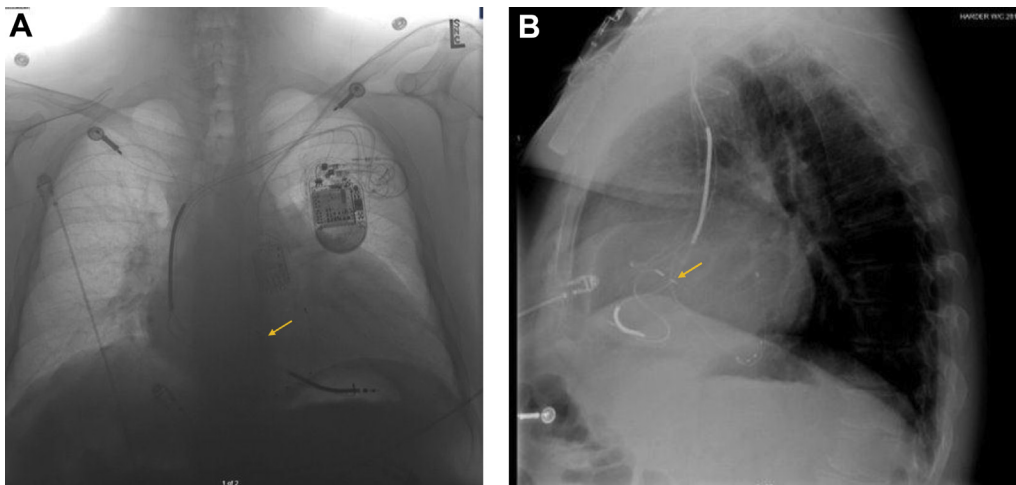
A: A negative image of the patient's chest radiograph, posteroanterior film demonstrating His bundle lead positioning (arrow). B: A lateral radiograph film, demonstrating the His bundle pacing lead (arrow).
